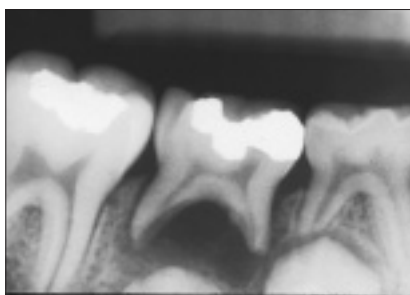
Failure of a direct pulp cap in tooth 85, with furcation involvement and development of a periapical abscess.
